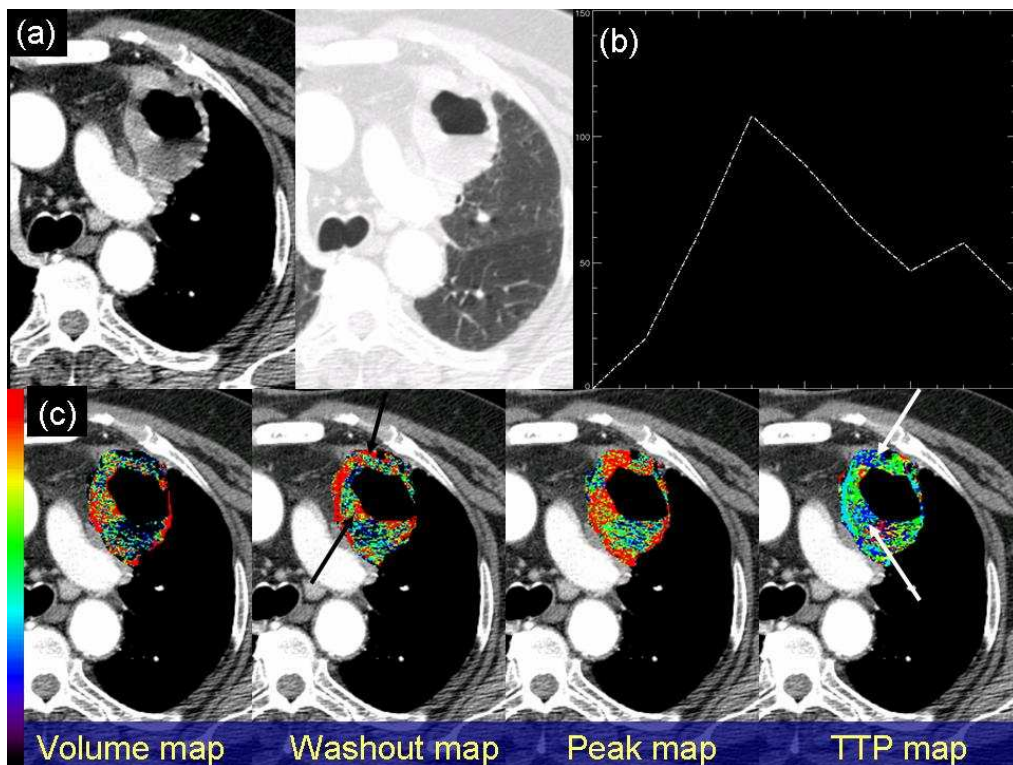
Chest CT and parametric perfusion maps in a 35-year-old man with squamous cell carcinoma in the left upper lobe apicoposterior segment.
